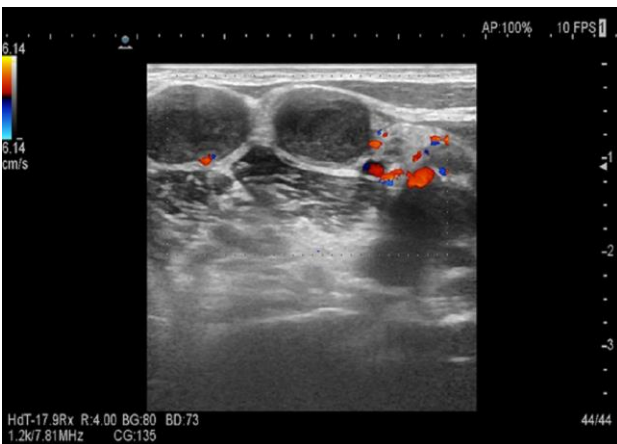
Colour doppler of a vascularity in lymph node.
